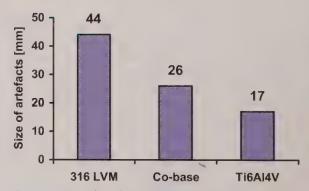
Size of artefacts during MRI scanning
